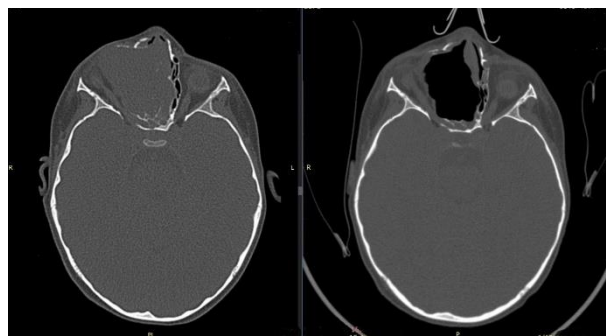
Comparative axial CT, preoperative (left) and postoperative (right)
